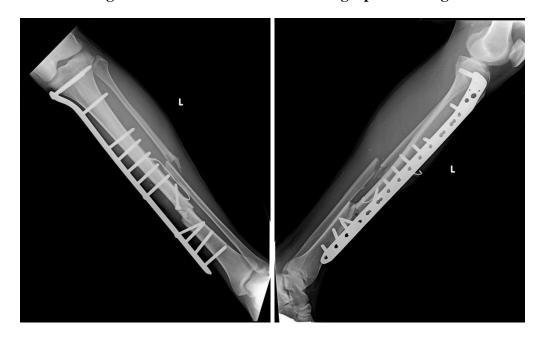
AP and Lateral radiograph of left leg at 6 weeks follow up
